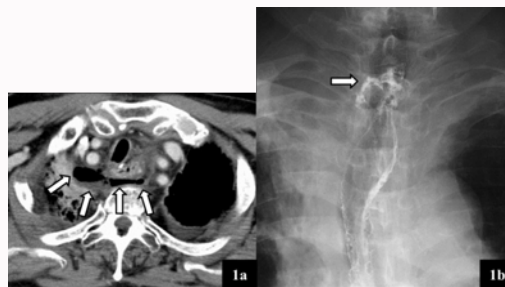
a: Computed tomography showed mediastinal abscess (arrow). b: Swallowing contrast study demonstrated anastomotic leakage (arrow).
